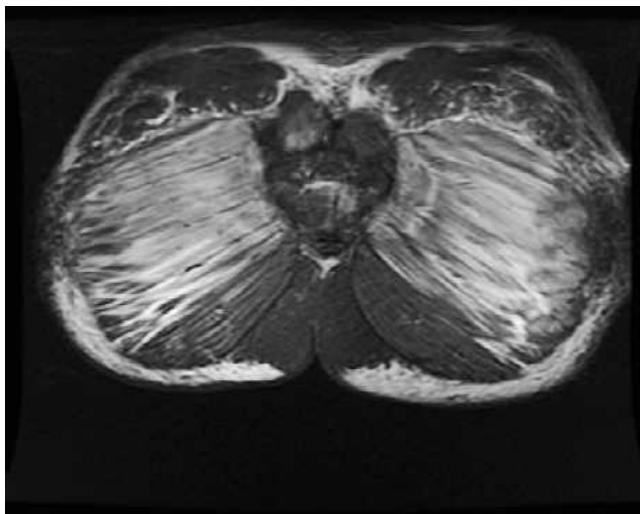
Magnetic resonance imaging showing extensive edema within the gluteal muscles, specifically the gluteus maximus, the right gluteus medius, and the anterior compartment of the left lower extremity.
